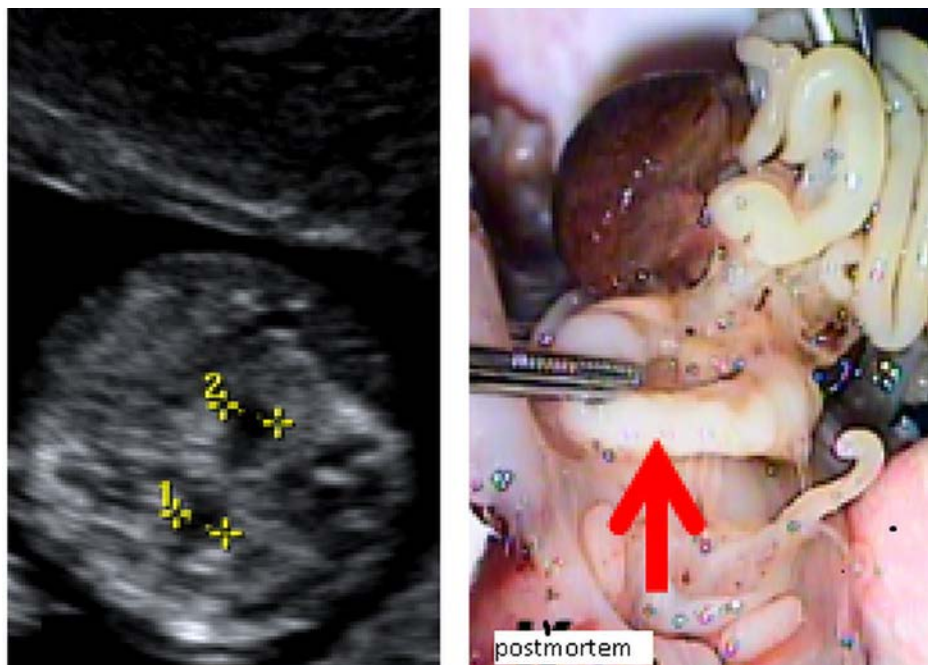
Case 2. Ultrasound kidneys' features at 12+3 WA: mild bilateral pyelectasis. Multiple associated additional markers for chromosome anomaly (cardiac anomaly, clenched hands, hypoplastic nasal bone) were found. Karyotype (from chorionic villus sampling) at 12+4 WA confirmed trisomy 18. Postmortem autopsy revealed horseshoe kidneys.
